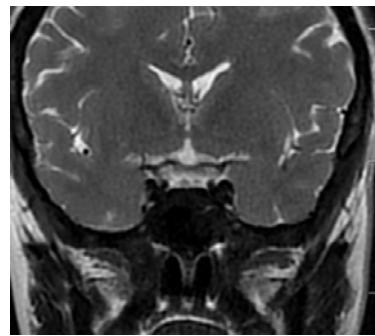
Pituitary MRI: Hemochromatosis of the pituitary gland (Case 2)
